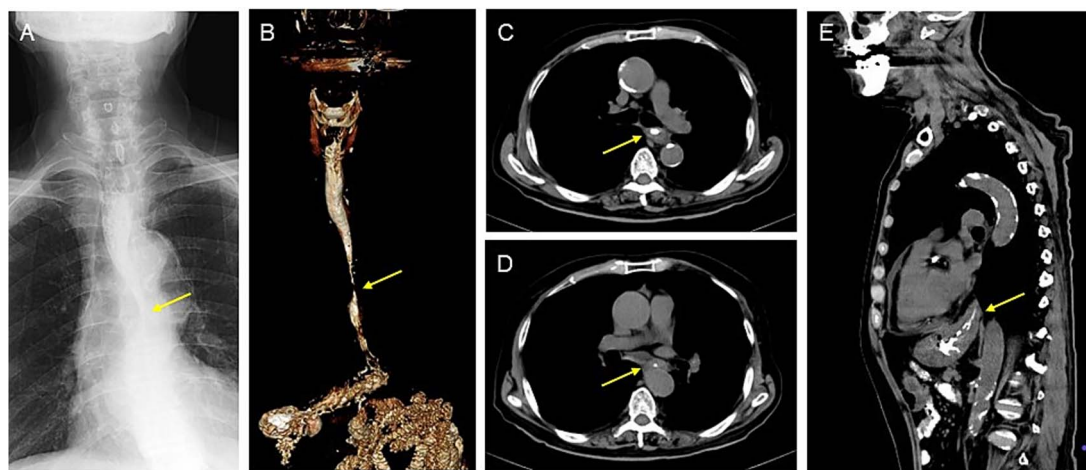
(A) A barium meal examination and (B) a three-dimensional computed tomography (CT) scan revealed a stricture with gradual narrowing of the calibre in the mid-oesophagus (arrows). (C, D) circumferential wall thickening in the mid-oesophagus and (E) a hiatus hernia are confirmed on the CT images (arrows).
